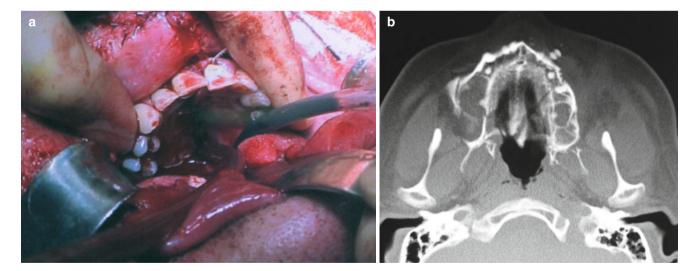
Split palate (a) and CT appearances of segmental split of palate (b)
